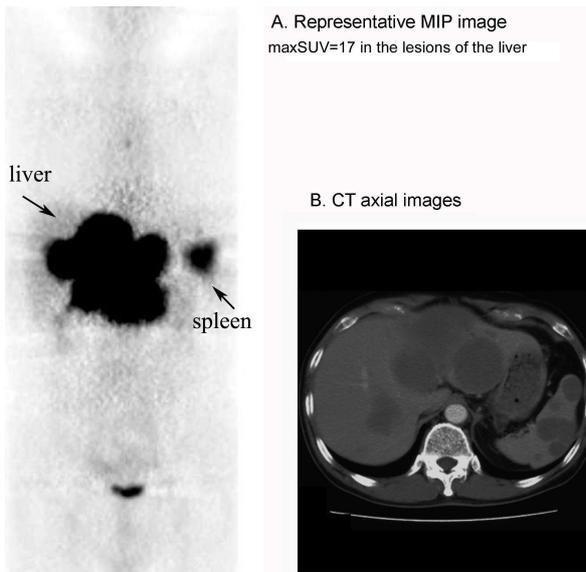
A, MIP image. B, Representative axial CT images. Strong FDG accumulation was observed in multiple regions in the liver and spleen, corresponding to the tumor detected by CT. (A and B). SUV_{max} was approximately 17 in the affected liver tumor. The pattern of the accumulation was homogeneous, round and very intense. Black arrows show the uptake in liver and spleen. In addition, FDG uptake was increased in front of the thoracic vertebrae; however, this region was examined by CT and the lesion was determined to be due to degeneration of the vertebral body because there were no apparent enlarged lymph nodes. Whole-body PET scan did not show any evidence of lymph node involvement or distant metastases, and this was confirmed by CT.
